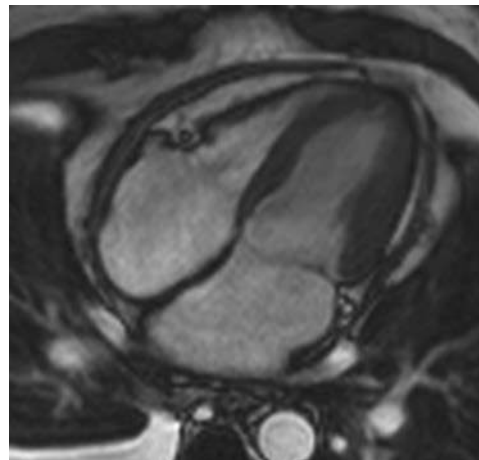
Cardiac magnetic resonance image showing a thickened pericardium in a patient with constrictive pericarditis. (Courtesy D. Didier, MD, University Hospital Geneva, Switzerland.)
